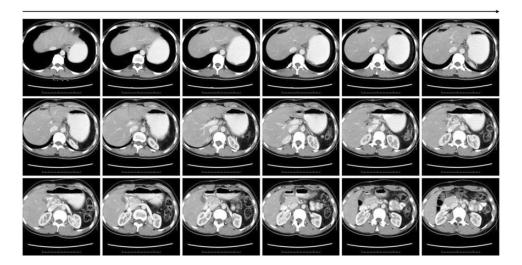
One-year postoperative computed tomography images.
